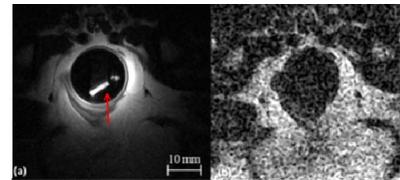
MR image of endoluminal coil (a) compared to external coil (b). T2-weighted TSE sequence with a TR/TE of 3000/94 ms, 70 mm FOV, 2mm slice thickness and a 156 x 222 μ m² pixel size was used for both acquisitions.
